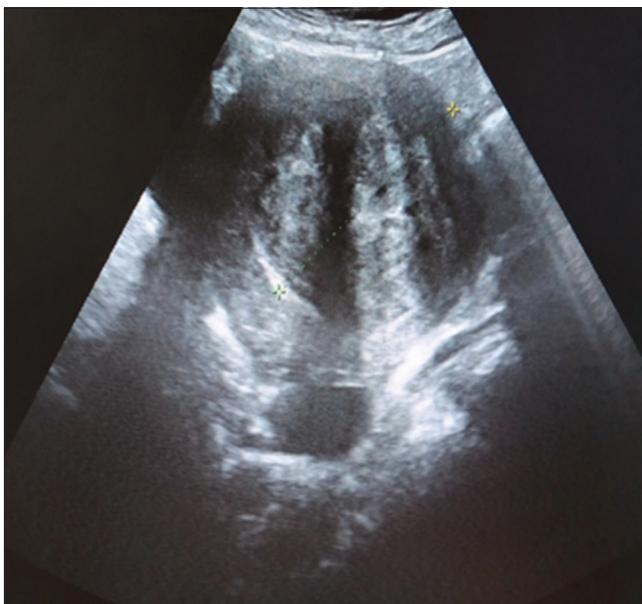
Ultrasound image of uterine fibroids
